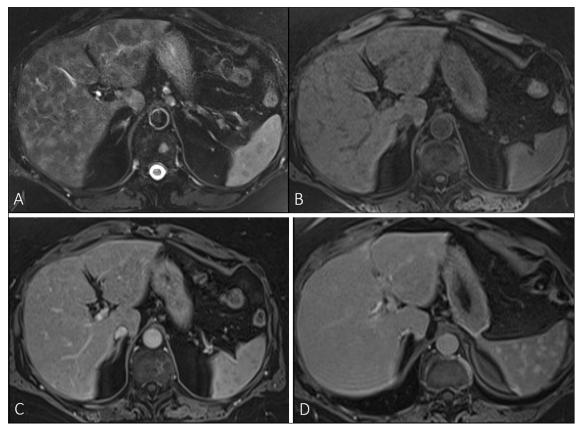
MRI of the upper abdomen at time of the initial diagnosis. Axial fat suppressed (FS) T2-weighted image (WI) (A), shows multiple hypointense liver and splenic lesions. Axial FS T1-WI before (B) and after administration of gadolinium-BOPTA contrast (C), show multiple hypointense focal lesions throughout the liver and spleen enhancing less than the surrounding liver and splenic parenchyma. FS T1-WI 1 hour after administration of gadolinium-BOPTA (D) shows delayed enhancement of the splenic lesions, whereas the liver lesions are not visible against the background of liverspecific enhancement of the normal liver.
